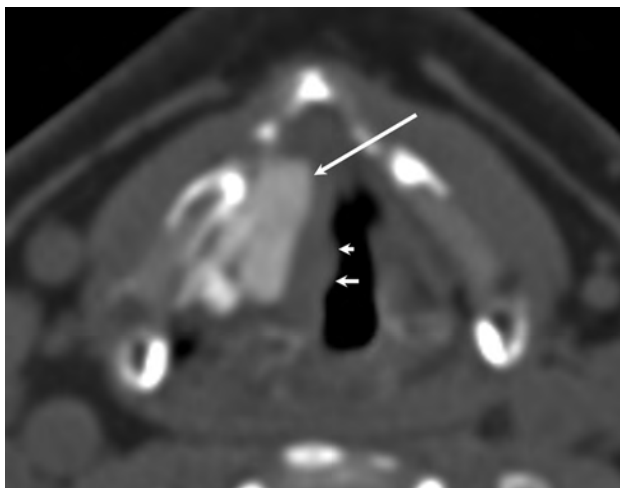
PTFE. Axial CT demonstrates hyperattenuating PTFE in the region of the right vocal fold with appropriate medialization of the right vocal fold. Note the slight nodular contour of the medial margin of the vocal fold (*smaller arrows*) indicating mild granuloma formation in this patient.
